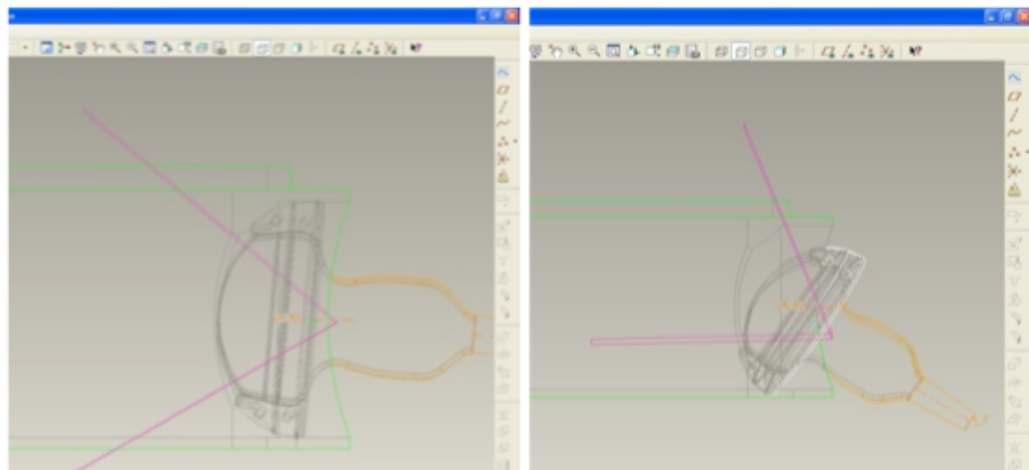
CAD modellings of the ultrasound FOV (Field of View) adjustments for the V2 scanner.
